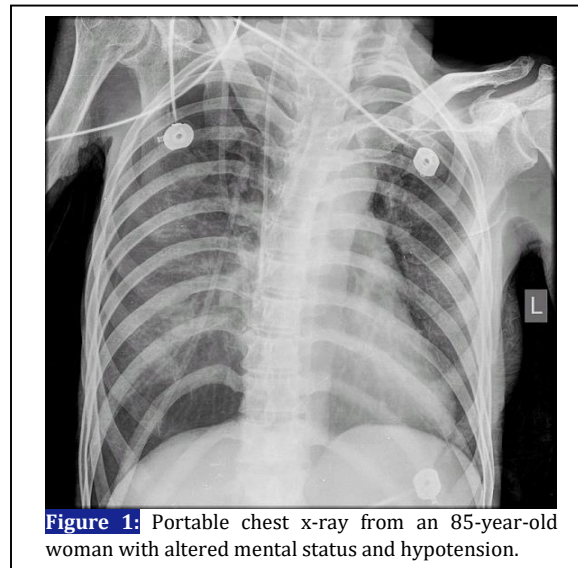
Portable chest x-ray from an 85-year-old woman with altered mental status and hypotension.
